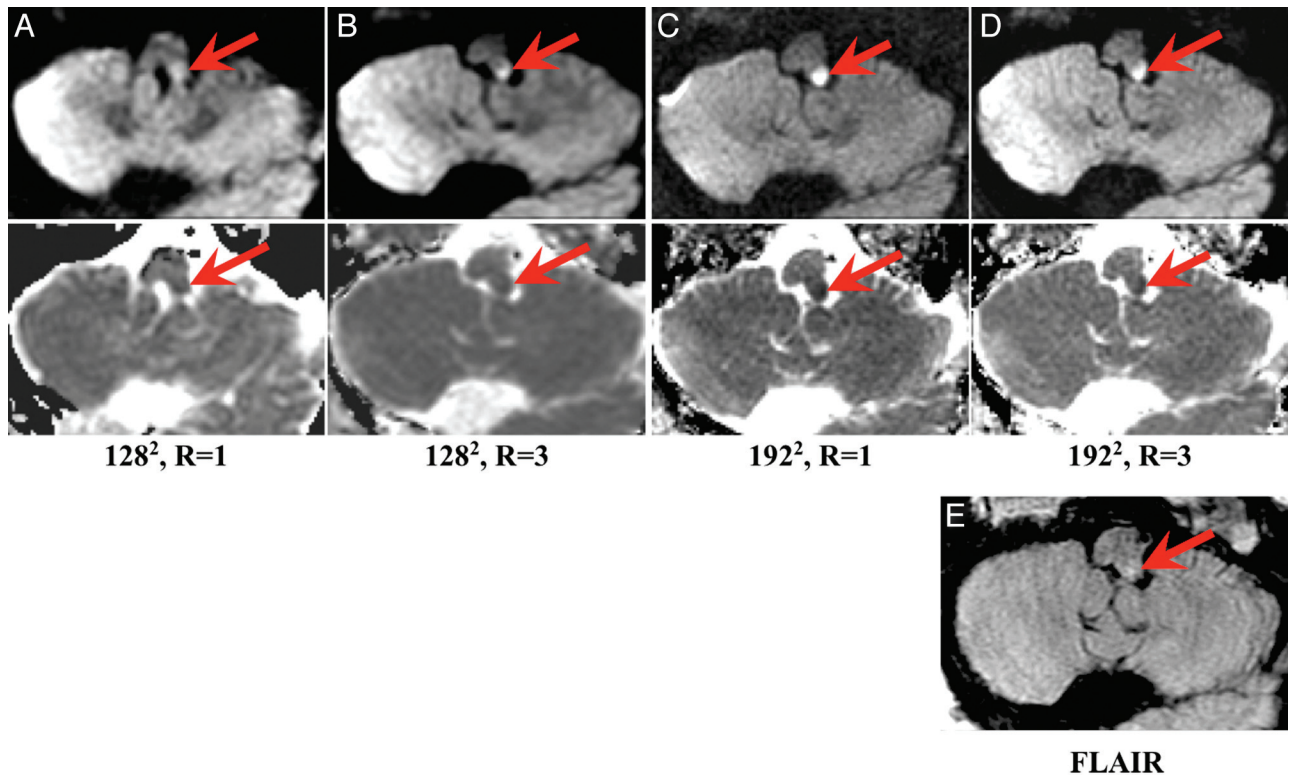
MR images of an 82-year-old patient with new onset of diplopia, who was found to have a left dorsolateral medullary infarct (*red arrow*) as depicted on representative diffusion images (upper row) and the corresponding ADC map (lower row) with matrix size and reduction factor as follows: *A*, 128^2 , $R = 1$; *B*, 128^2 , $R = 3$; *C*, 192^2 , $R = 1$; *D*, 192^2 , $R = 3$. Corresponding FLAIR image (*E*) demonstrates minimal associated edema suggesting acute onset. One of 3 readers graded the 128^2 , $R = 1$ and 128^2 , $R = 3$ scans as having “no lesion” but correctly graded the higher matrix size scans (192^2 , $R = 1$ and $R = 3$) as infarct, highlighting the increased conspicuity of the lesion by using a higher matrix size. The 2 remaining readers correctly graded this lesion for all presented imaging parameters.
